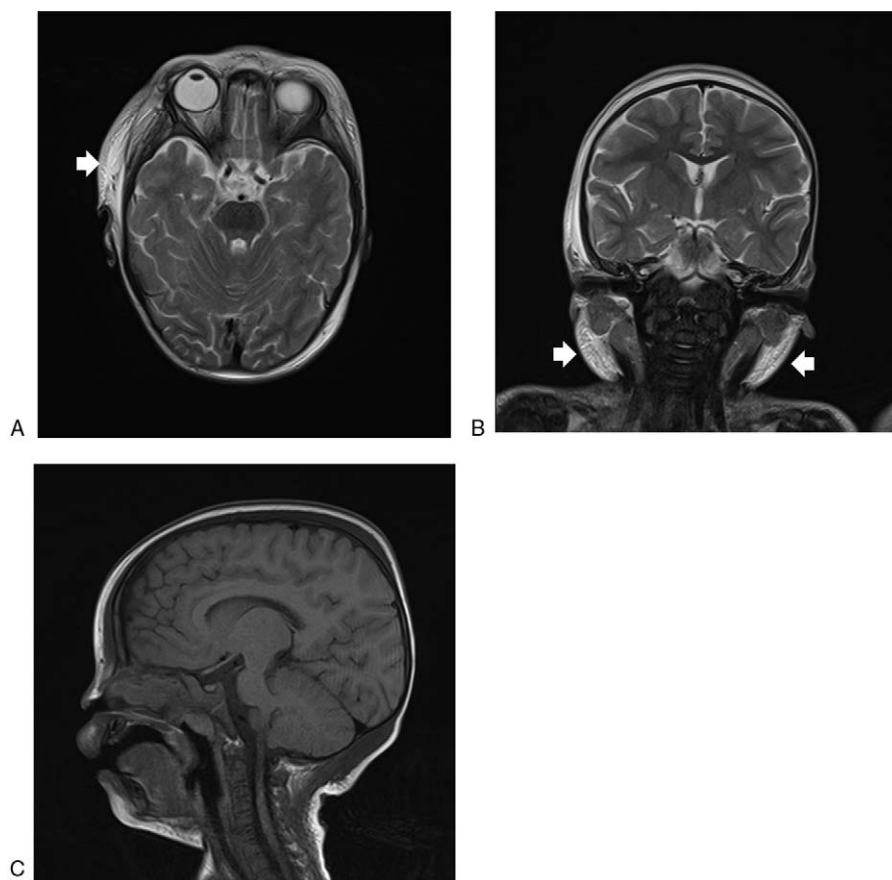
Magnetic resonance imaging findings. (A) Axial T2-weighted image; (B) coronal T2-weighted image; (C) sagittal T1-weighted image. Myeloid sarcomas are visible as hyperdense ill-defined subcutaneous tumors on the T2-weighted images (arrows). No lesions are evident in the brain. Specifically, there are no apparent abnormalities in the pituitary gland or hypothalamus.
